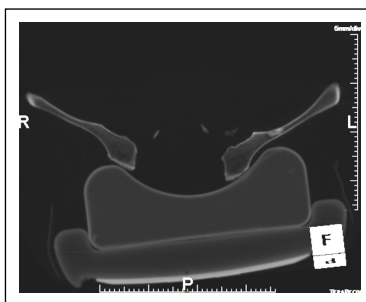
CT image of the iliac bones that shows the irregularly hyperdense oval area with irregular margins, thick and thickened, of about 20mm, localized at the level of the proximal third of the left iliac wing, in the context of which, in the most medial part is appreciable initial lytic component.
